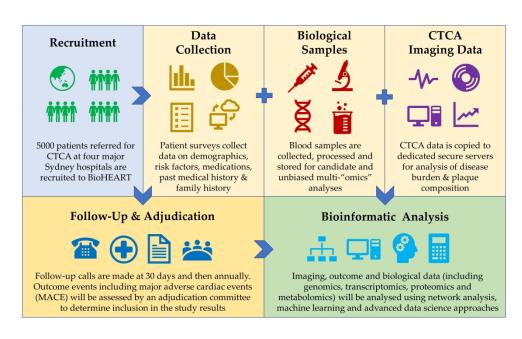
BioHEART-CT Study Design
